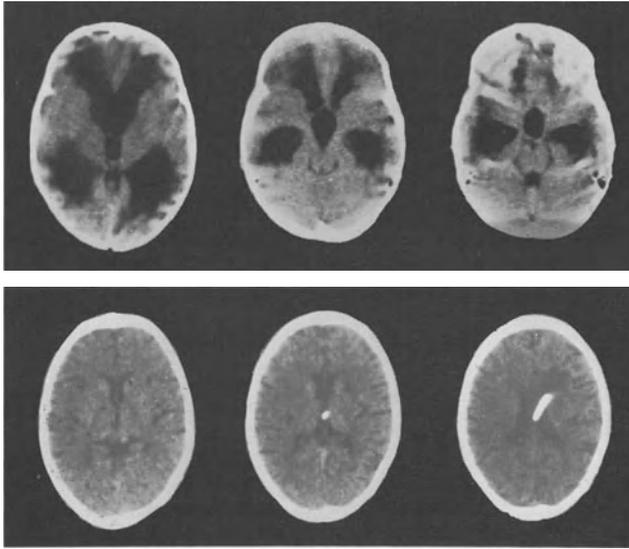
Pre- (*left*) and 2 months postoperative (*right*) CT. Note subependymal periventricular edema (*left*)
